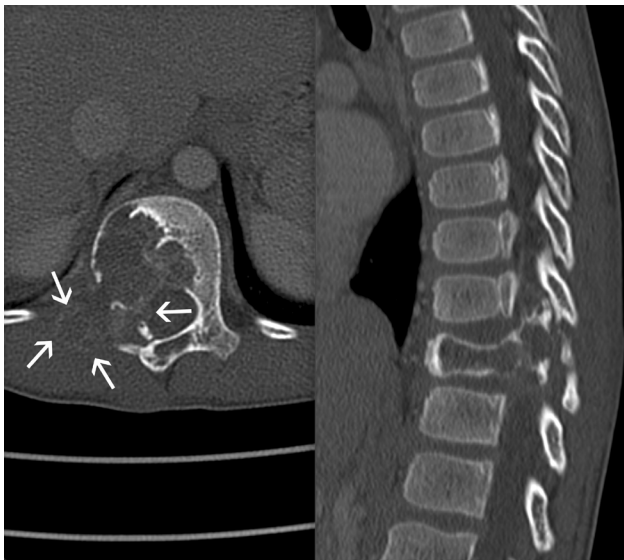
Aggressive osteoblastoma of T11 in an 8-year-old boy. Axial and sagittal CT images showing a lytic lesion involving the right posterior elements and most of the vertebral body (with moderate collapse), cortical breakthrough, and a soft-tissue component (straight arrows) extending into the paravertebral muscles and spinal canal, without appreciable matrix mineralization.
